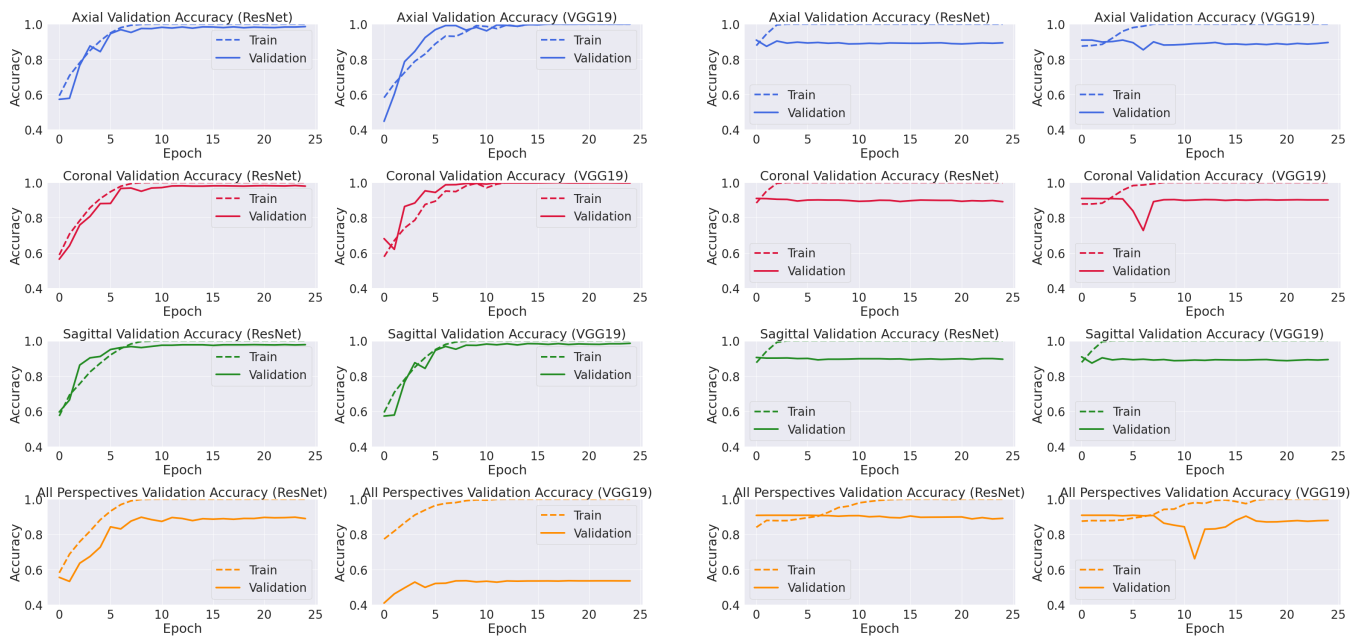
Training and Validation Curves for ResNet and VGG-19 on Schizophrenia (left) and MDD (right) 2D MRI-slices.
